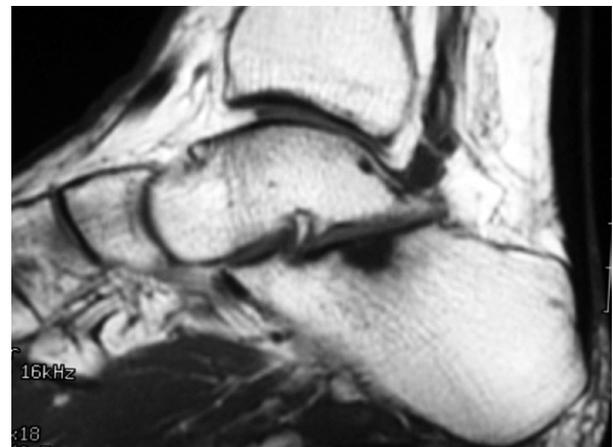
Magnetic resonance image showing hypersignal in the talocalcaneal area of the calcaneus surface.
